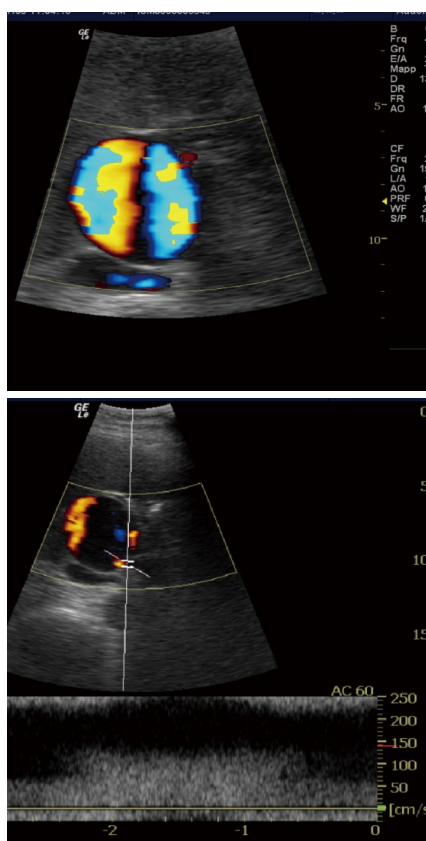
Color-Doppler US shows a turbulent flow inside the aneurysm (red and blue color). An increase velocity of flow is detected at the origin of the aneurysm.
